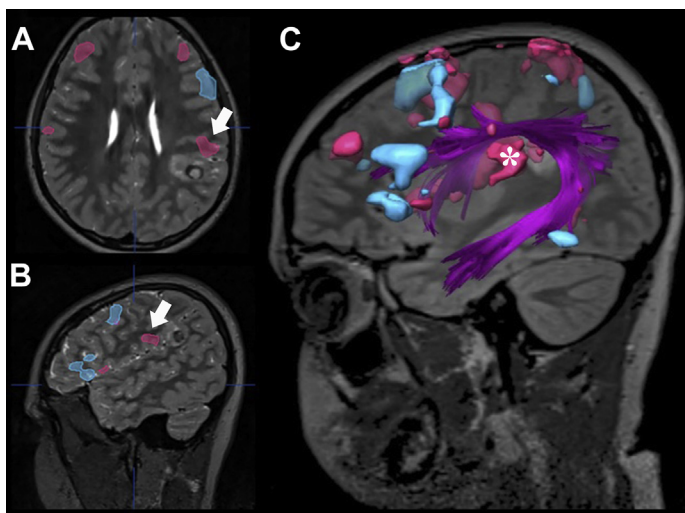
Superimposing the DTI data to the functional MR imaging task data can increase confidence in mapping atypical language centers. (A, B) Axial and sagittal 3D-T2 images with coregistered verb generation (*blue*) and semantic decision (*red*) tasks for a left parietal extraventricular neurocytoma. There is a dominant receptive language center (*arrows*) in an atypical location in the supramarginal gyrus. Activity was not seen in the classic Wernicke location of posterior superior temporal gyrus. (C) 3D-FLAIR fused with left AF volume (*purple*) shows the streamlines involving the receptive language center (*asterisk*) increasing confidence. There was impairment of phonologic retrieval during intraoperative cortical stimulation of this center.
